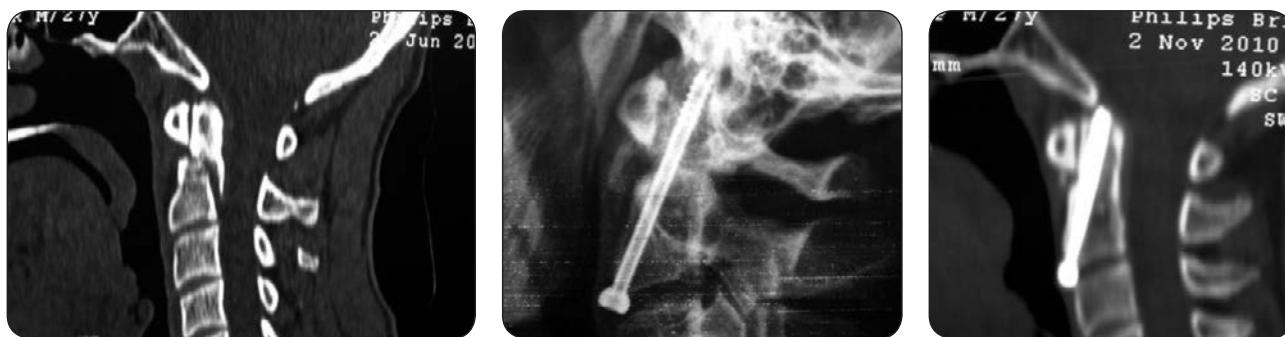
WG, 27 year old male sustained an Odontoid type IIB. 12 months post x-ray showing bony healing, confirmed by a CT scan.
